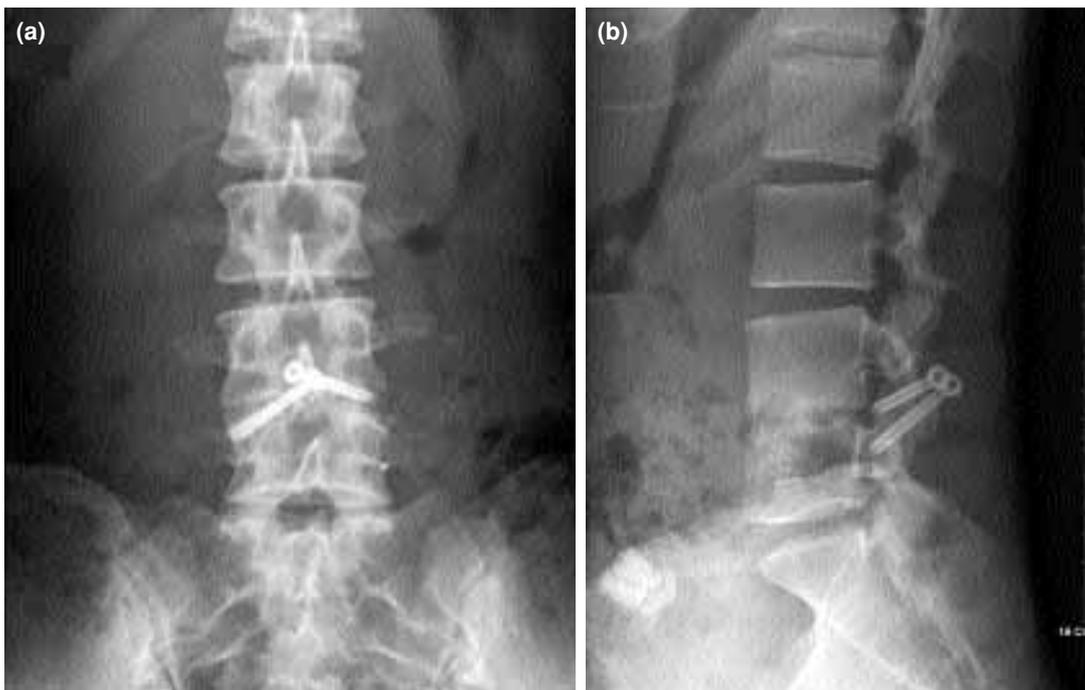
(a) Anteroposterior and (b) lateral radiographs obtained a year after anterior fusion with posterior facet screw fixation. Union is complete with relief of symptoms.
